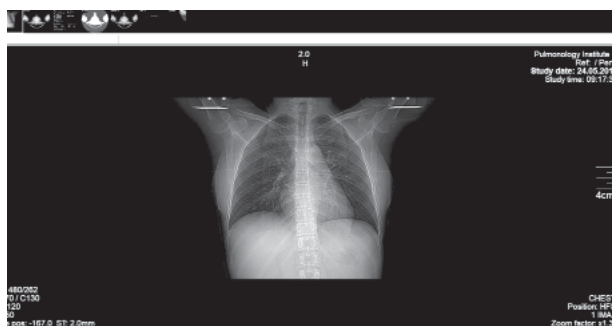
X-ray of the patient at the initial request for help, direct projection
